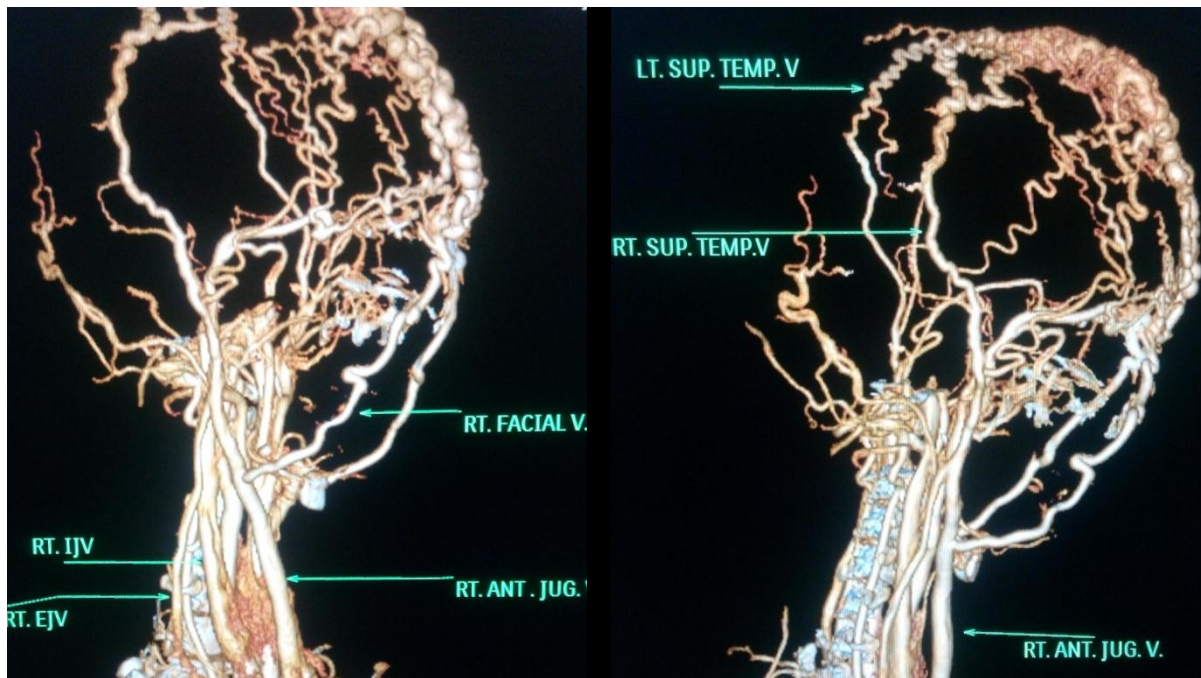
3D CT Angiography images showing the venous drainage of the cirroid aneurysm of the scalp.
